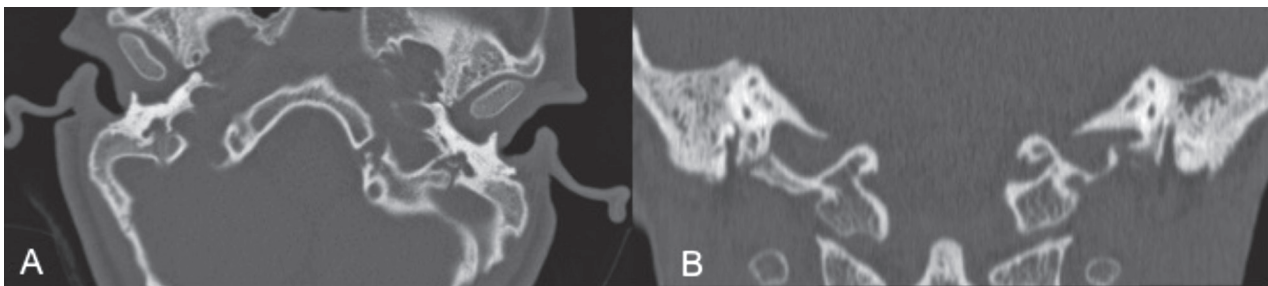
High resolution computed tomography (A: axial view; B: coronal view) showing typical findings in Turner Syndrome: stenotic external auditory canal, directed posteriorly and superiorly, and more oblique than usual; prominence of conchal cartilage obstructing the meatus; para-transverse direction and increased angle of major axis of the petrous bone (45° instead of 30°); contracted mastoid with low cellularity
